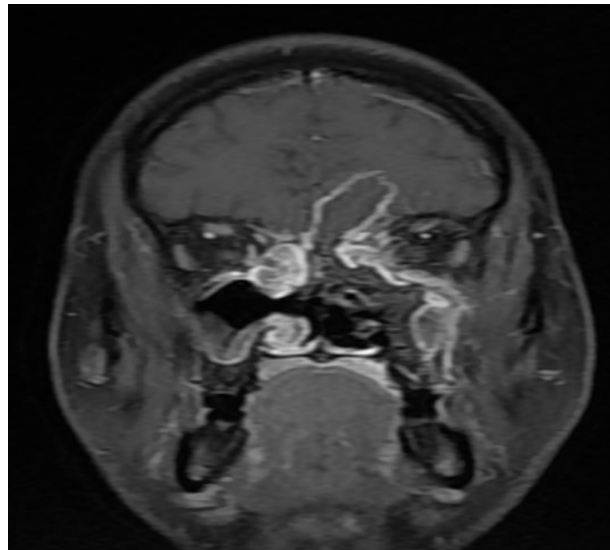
MRI image shows coronal T1WI post contrast image showing peripherally enhancing lesions extending into left frontal lobe
